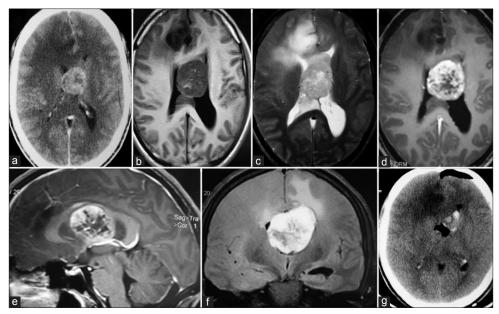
(a) Contrast enhanced computed tomogram head showing a well-defined hyperdense intraventriuclar lesion. (b-d) MRI axial images showing well-defined T1 hypo, T2 hyperintense lesion occupying the body of both lateral ventricles well enhancing with central hypointensity and another ill-defined lesion in the right frontal lobe. (e) Sagittal MRI showing the lesion pushing the body corpus callosum superiorly. (f) FLAIR coronal image showing hyperintense lesion. (g) Postoperative Non contrast computed tomogram showing total excision
